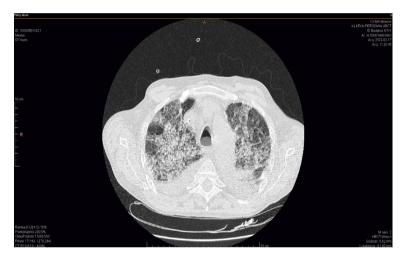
High-resolution computed tomography lesions of the chest, in the course of diffuse alveolar hemorrhage
